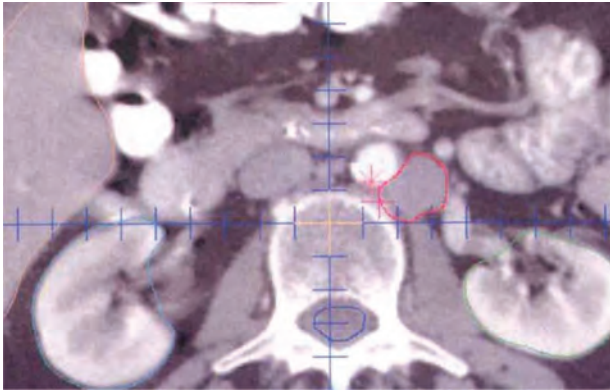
Enlarged para-aortic node, contoured in red, visible on an axial CT slice.
